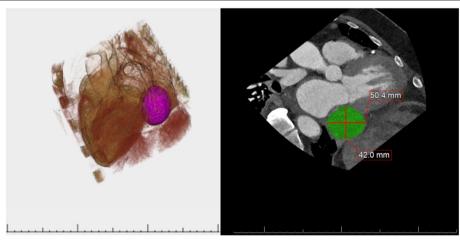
Cardiac computed tomography with 3-dimensional rendering of left ventricular pseudoaneurysm (LVP) (left) and approximate size noted on axial view (right)
